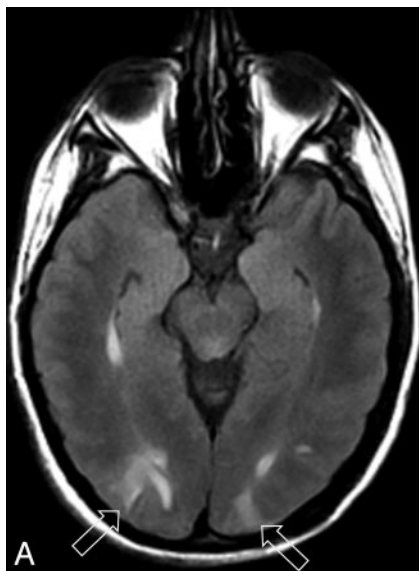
Patient 10 is a 27-year-old man with a history of drug and alcohol abuse with a necrotic pneumonia and empyema growing *Pseudomonas* and *Klebsiella*. He developed altered mentation and an asymmetric neurologic examination with blood pressures ranging between 130/77 and 130/100 mm Hg. *A*, Axial MR imaging (FLAIR sequence) demonstrates extensive vasogenic edema in the occipital lobes (*open arrows*) and temporooccipital junction (*arrowheads*) consistent with PRES. Additional extensive areas of vasogenic edema consistent with PRES judged vasogenic edema grade 4 were present in the frontal and parietal lobes (*not shown*). *B*, Vertebral catheter angiogram obtained after development of occipital hemorrhage (5 days after initial toxicity) demonstrates areas of vessel narrowing and dilation along with a string-of-bead appearance and areas of focal spasm in parietal and occipital branches of the PCA. Right common carotid catheter angiogram (*not shown*) also demonstrated extensive vasospasm in branches of the ACA and MCA. *C*, MR angiogram obtained 5 days after catheter angiogram (10 days after initial toxicity) demonstrates persistent vessel irregularity in the posterior cerebral branches (*arrows*) with a pattern nearly identical to the appearance of the catheter angiogram. Follow-up MR imaging demonstrated improvement of the extensive vasogenic edema.
